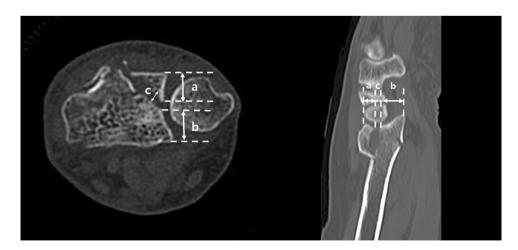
Pre-surgical CT scan shows articular involvement of the dorsoulnar fragment. Distal radius fractures with a dorsoulnar fragment that involved more than one-quarter of the articular surface were included in this study. The measurement method to determine articular involvement was the length of the dorsoulnar fragment
